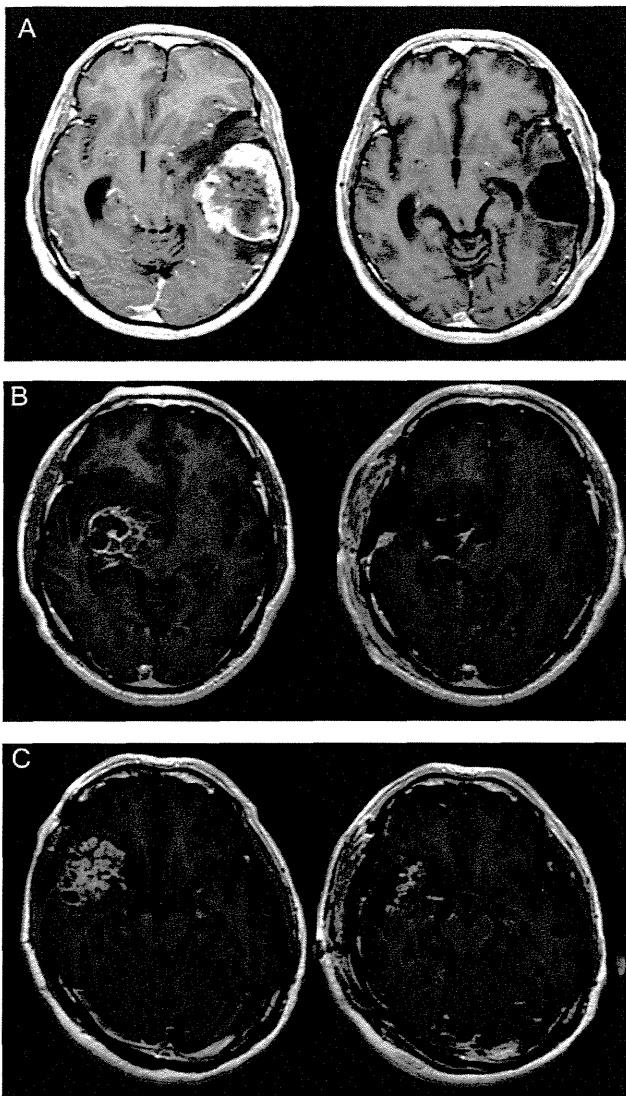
Pre- (left) and post-operative (right) axial T1-weighted magnetic resonance imaging with contrast enhancement in patients who underwent resection of high-grade gliomas. (A) 'Complete resection' without any residual pre-operative contrast enhancement lesion. (B and C) 'Incomplete resection' with residual small enhancement lesion around the resection cavity (B) or residual nodular contrast enhancement (C).
